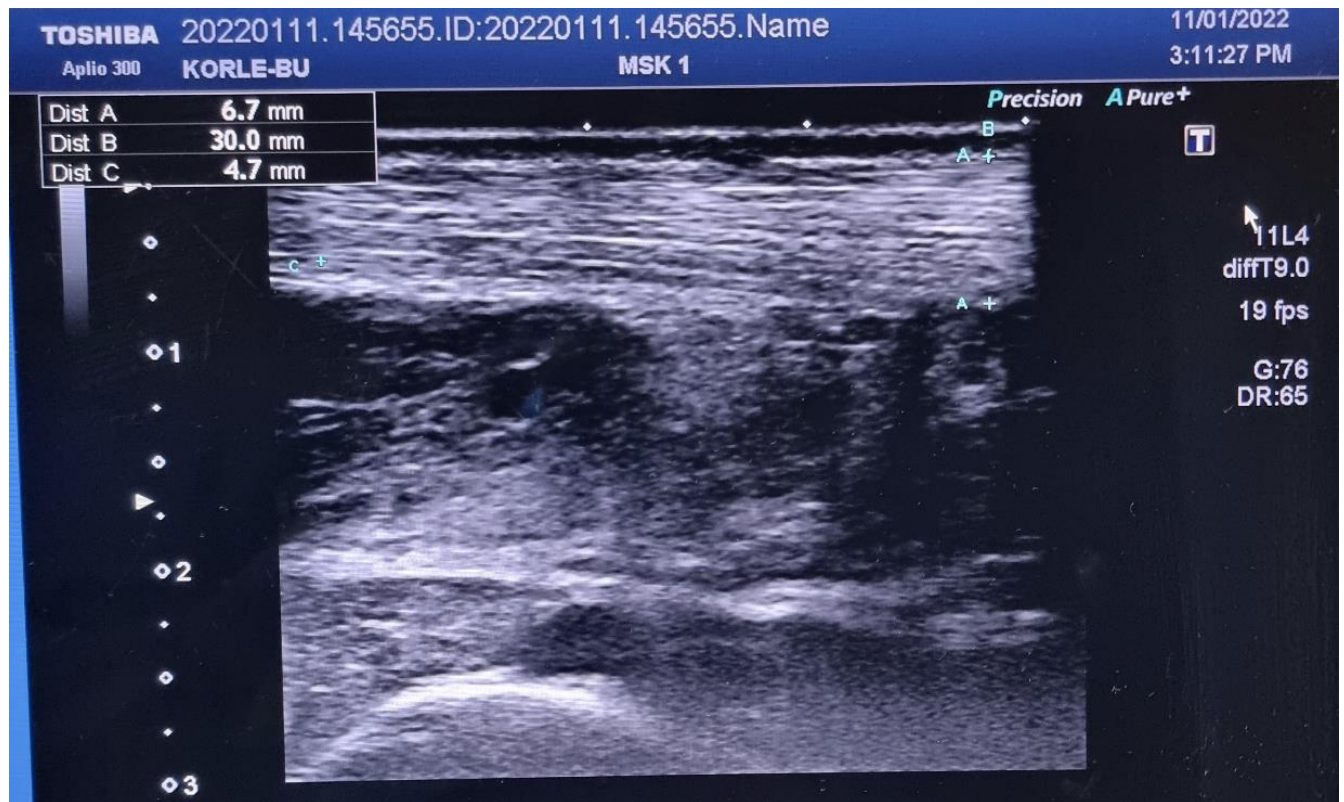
grey scale longitudinal ultrasound image of the right AT of participant number 113. The AT shows a normal uniformly hyperechoic, fine fibrillar pattern.
